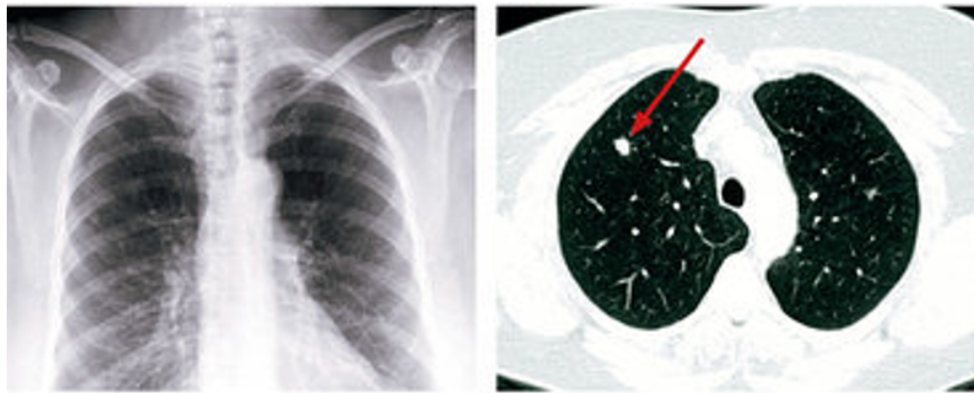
The chest X-ray and Ct Scan of the same patient, X-ray did not reveal any lesion because of the overlapping 2D image but when CT Scan was taken a small malignant nodule was observed (red arrow) [16].
